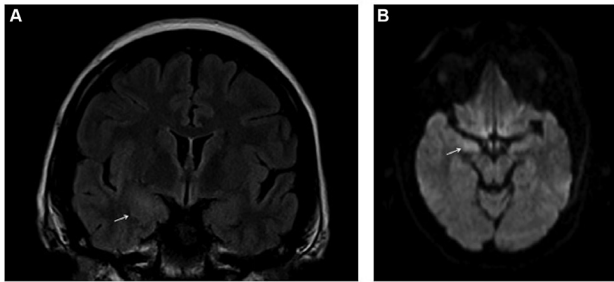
(A) MR scan of the brain, axial T2-weighted image showing subtle hyperintense signal in the right amygdala region with mild gyral expansion (arrow). (B) Axial diffusion weighted image revealing associated restricted diffusion in the right amygdala (arrow).
